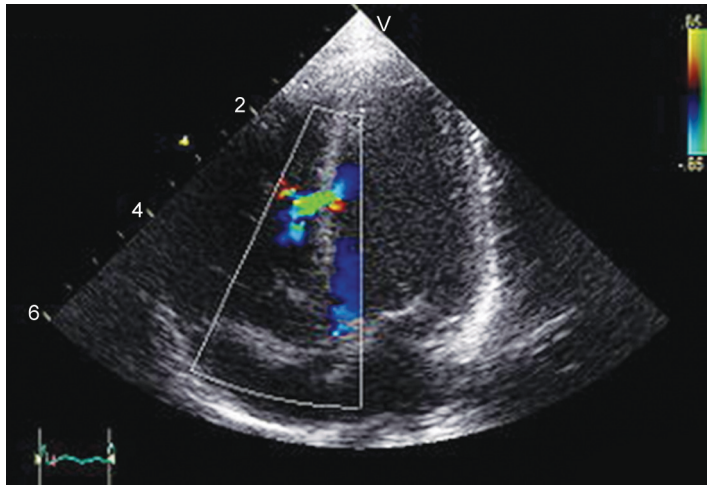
Echocardiographic image of ventricular septal defect
